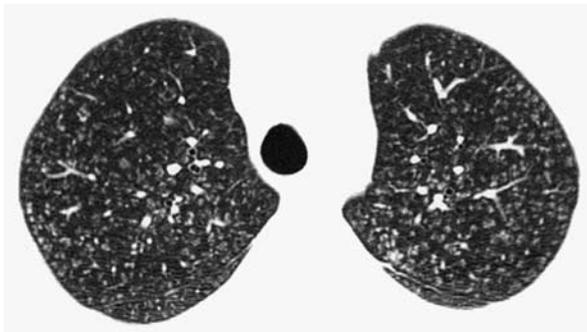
Centrilobular nodules. Diffuse ground-glass centrilobular nodules are seen on this axial HRCT image of a patient with subacute HP. Pathologically this corresponds to interstitial inflammation that is bronchiolocentric.
